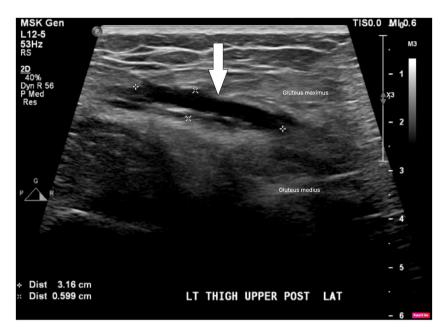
Ultrasound image of left gluteal region showing a collection of 3.1×0.5 cm in the intermuscular plane.
